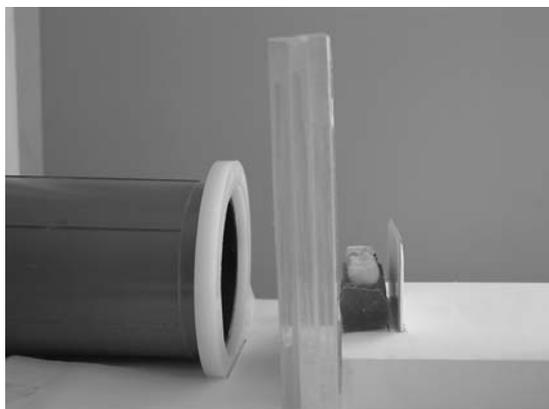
The arrangement for identical X-ray projection.
